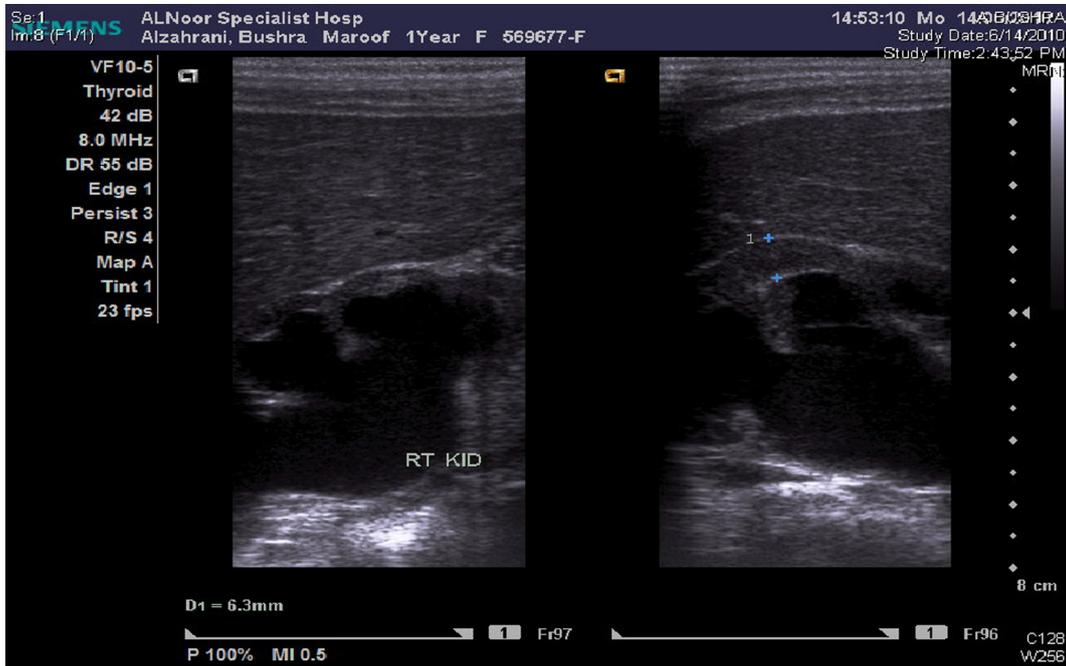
Ultrasound of the kidney - 1.
